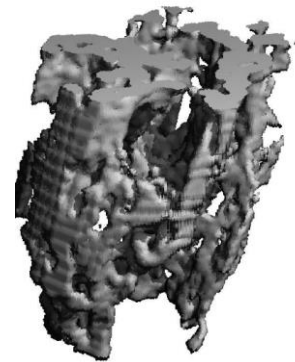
Micro CT Imaging Data: From the above micro – CT data, we can clearly observe that the overall cortical and trabecular bone volume seems to be more in KO than Control, although most of bone is porous in KO (red arrows) at P10.
